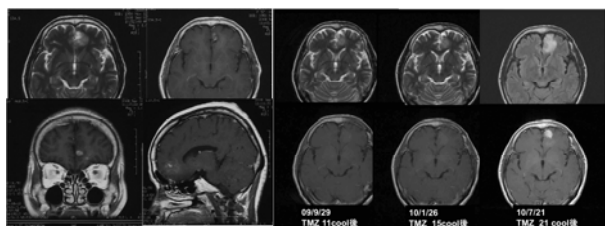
MRI at the onset of grade II glioma (left), and serial progression with TMZ (right).
